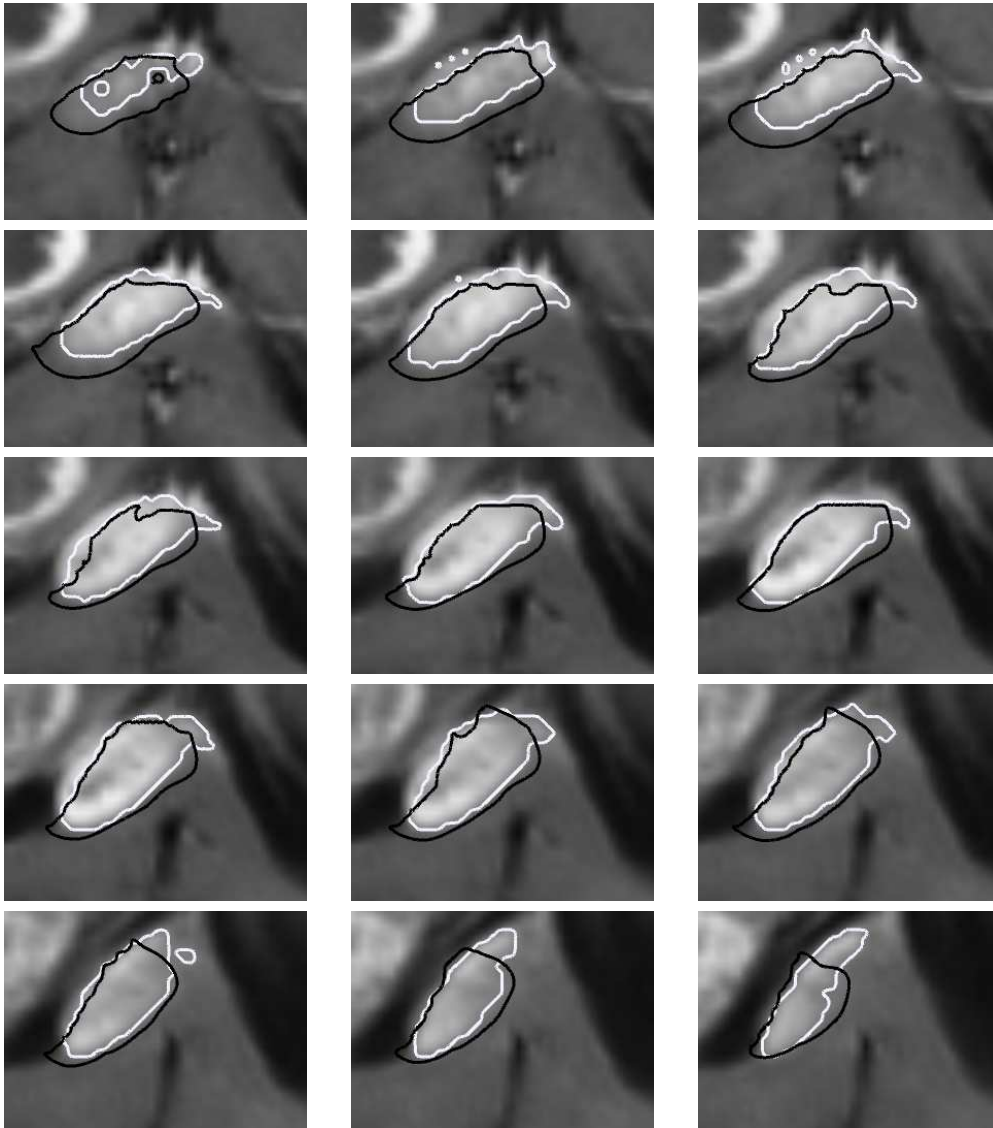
The MR image taken at the third time point for the first patient. The white contour denotes the manual delineations and the black contour is the estimated evolution of the tumor delineation.
